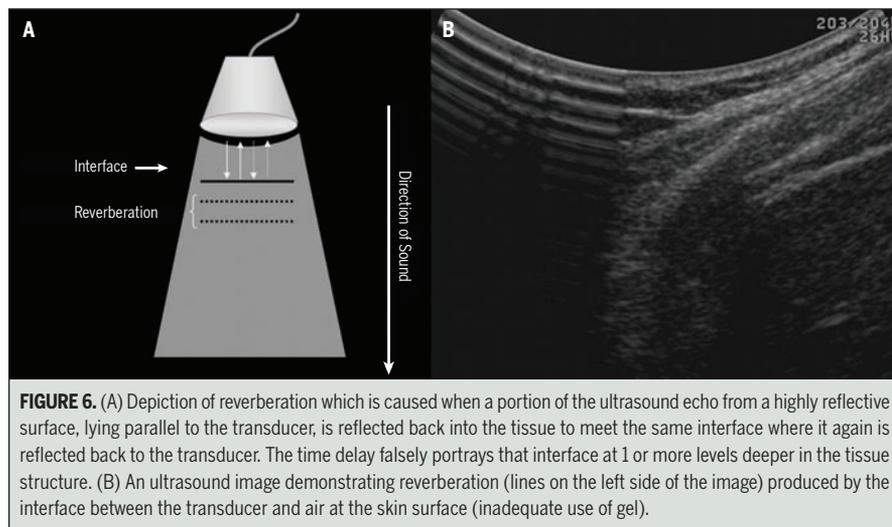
(A) Depiction of reverberation which is caused when a portion of the ultrasound echo from a highly reflective surface, lying parallel to the transducer, is reflected back into the tissue to meet the same interface where it again is reflected back to the transducer. The time delay falsely portrays that interface at 1 or more levels deeper in the tissue structure. (B) An ultrasound image demonstrating reverberation (lines on the left side of the image) produced by the interface between the transducer and air at the skin surface (inadequate use of gel).
